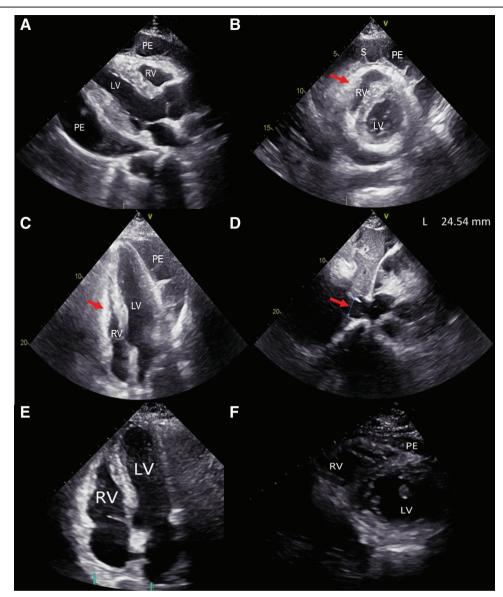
Transthoracic echocardiogram revealed septated, fibrinoid pericardial effusion and right ventricular diastolic compression. Images after the pericardial window procedure revealed minimal residual pericardial effusion and resolution of right ventricular compression. A comparison of images before and after the procedure can be seen as follows: (A) parasternal long-axis view in end-diastolic phase; (B) right ventricle compression in diastole in parasternal short-axis view; (C) right ventricle compression and indentation in late diastole in apical four-chamber view; (D) inferior vena cava diameter = 24.54 mm, consistent with inferior vena cava plethora; (E) apical four-chamber view after pericardial window; and (F) parasternal short-axis view after pericardial window.
